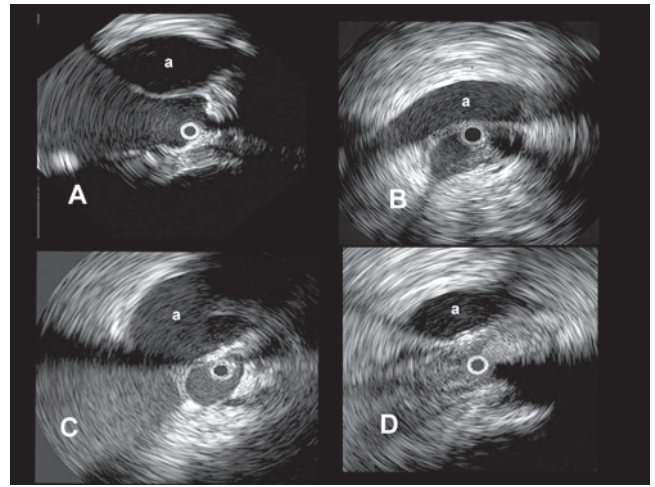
Images obtained by intravascular ultrasound (IVUS) at the site of an iliac vein compression. A. The right iliac artery crosses anterior to the left iliac vein, in this case creating moderate degree of compression. B. Compression of the iliac vein with an intraluminal web formation. C. A distinct septa underlying the compressing artery deforming and dividing the iliac venous lumen. D. Acute thrombosis of the compressed venous segment. The black circle inside the vein represents the inserted IVUS catheter (the a marks the right common iliac artery).
